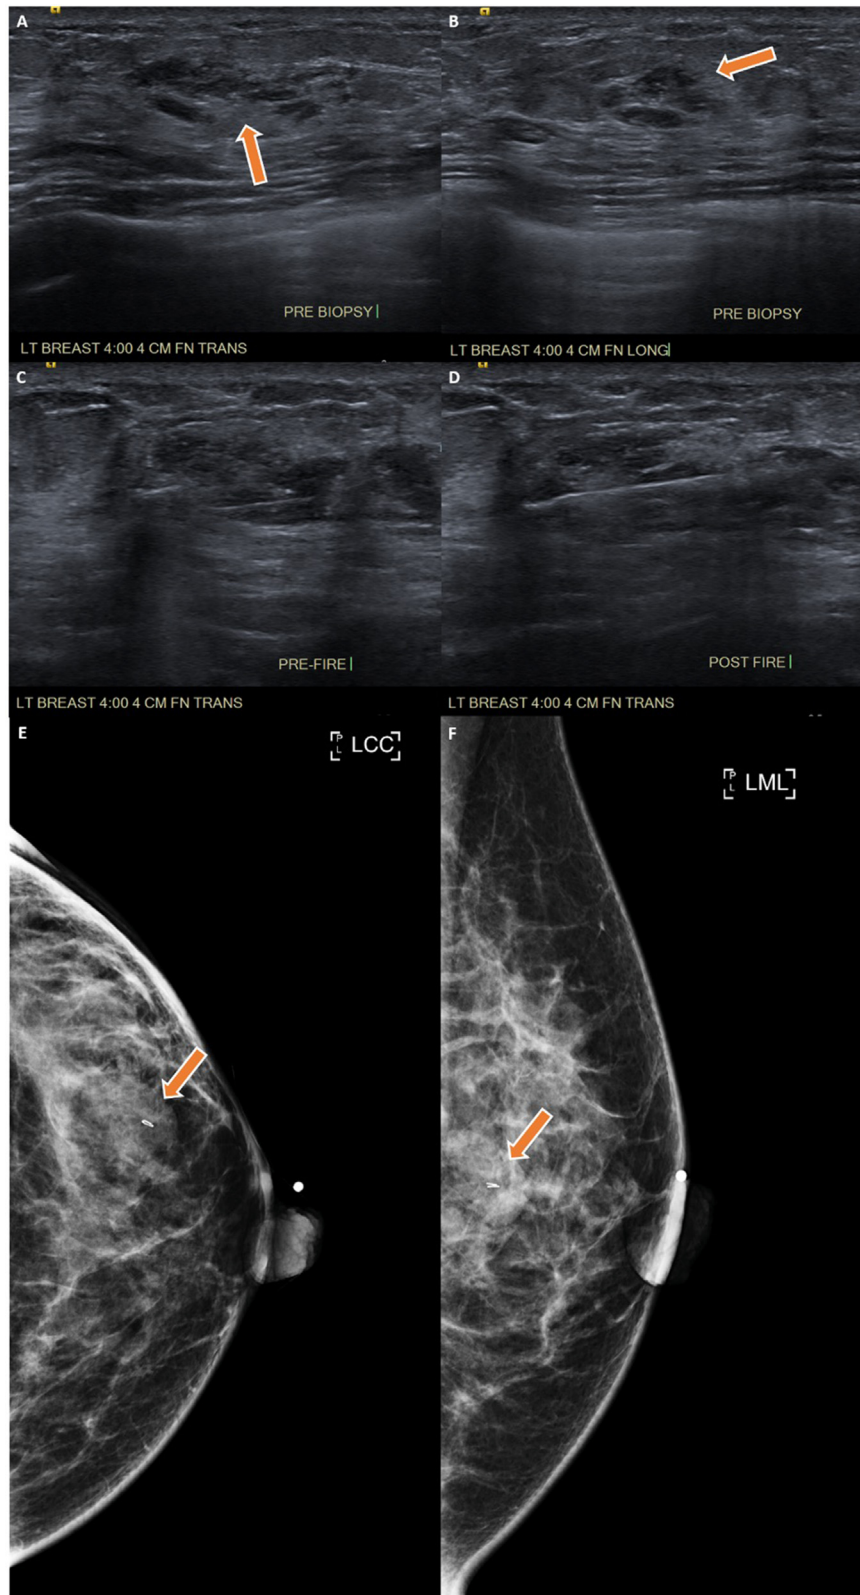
Images (A) and (B) transverse and longitudinal sonographic views demonstrate pre-biopsy appearance of circumscribed left breast mass (orange arrows). Image (C) demonstrate proper needle trajectory and image (D) confirms appropriate tissue sampling position postfire. Postbiopsy left breast mammogram, craniocaudal view (E) and mediolateral oblique view (F) demonstrate the biopsy clip in appropriate position within the mass (orange arrows) and no evidence of immediate postbiopsy hematoma.
